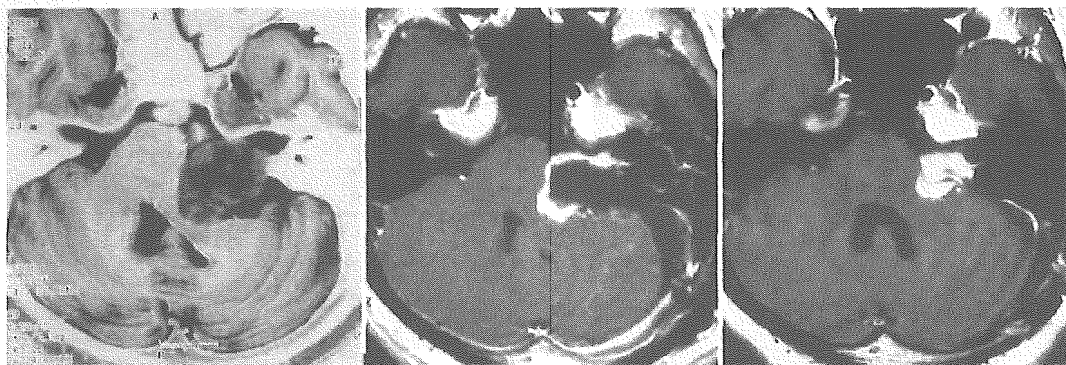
Magnetic resonance images demonstrating the region in which a VS is located. *Left:* A large tumor causing a marked brainstem deformity. *Center:* An intended partial resection was performed via a translabyrinthine approach, leaving a tumor boundary attached to the facial nerve. *Right:* Three months postoperatively, the residual tumor has shrunk spontaneously, remarkably reducing the brainstem deformity. The tumor is now treated with fractionated SRT (50 Gy in 25 fractions).
